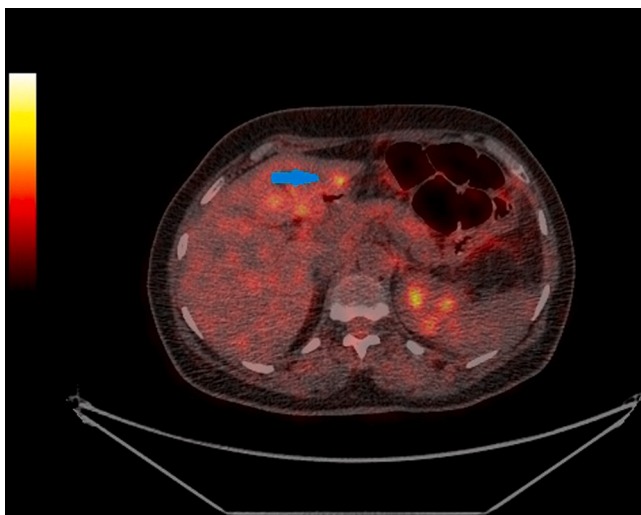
53 year old female patient with low grade to moderately differentiated adenocarcinoma of the colon found to have indeterminate/ equivocal/ suspicious lesion on anatomic follow up imaging and was evaluated by FDG PET/CT that showed high uptake in the liver lesions with subsequent surgery and biopsy of the lesions showing Nodular regenerative hyperplasia as a cause of the false positive uptake.
